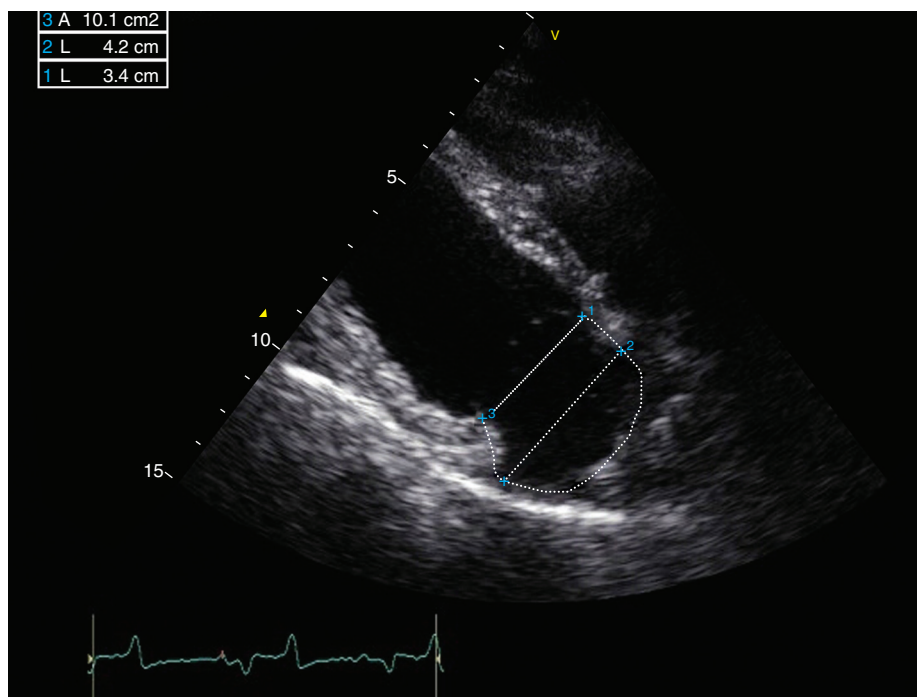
Right parasternal long-axis four-chamber view used to obtain an image of the entire left atrium in its largest dimensions and to measure the mitral annulus diameter (1), left atrial diameter (2) and left atrial area (3)
